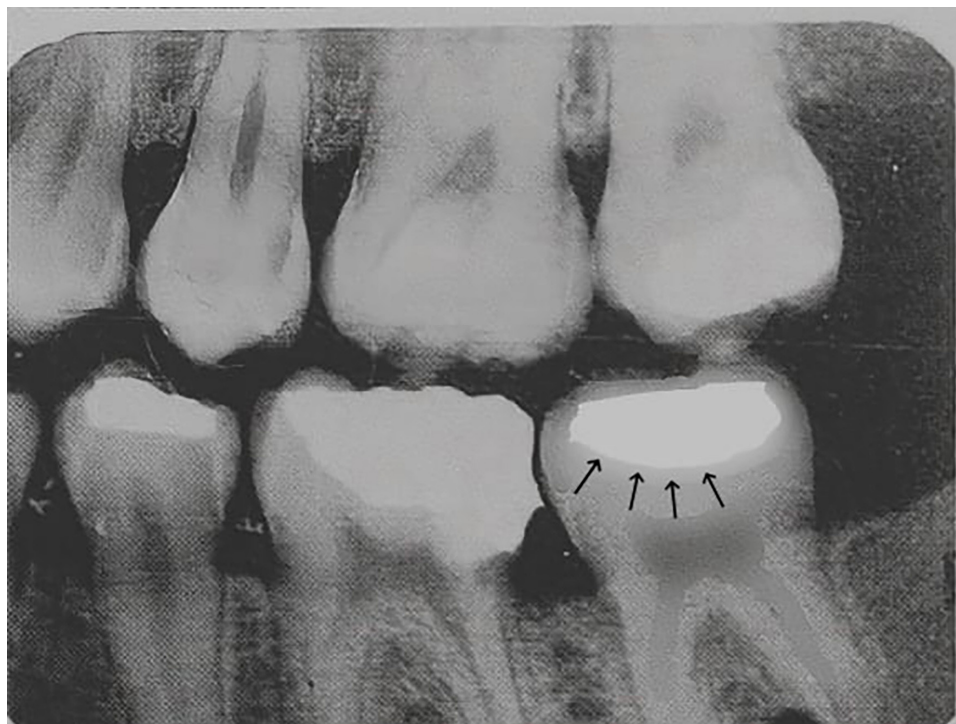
Pre op Bitewing. Arrows indicating carious lesion on tooth #37
